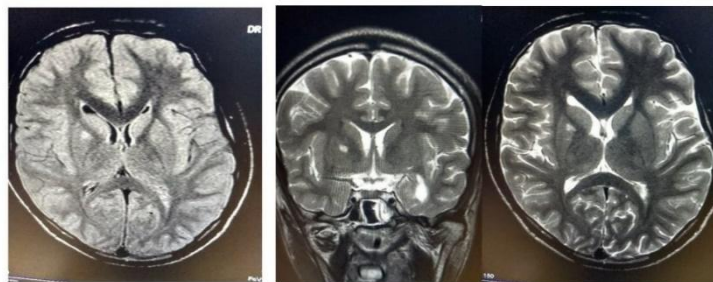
MRI Brain:Evidence of T2,Flair hyperintense lesion in the rt Globus pallidus suggestive of toxic encephalopathy
